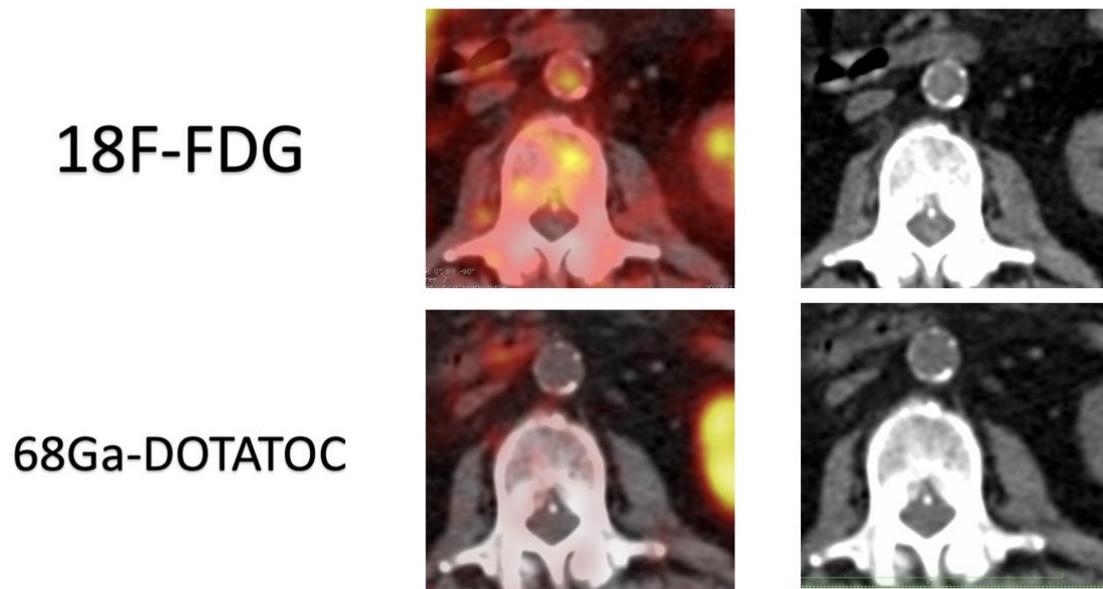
FDG-positive (upper panels), SSR-tracer negative (lower panels) arterial plaque.
